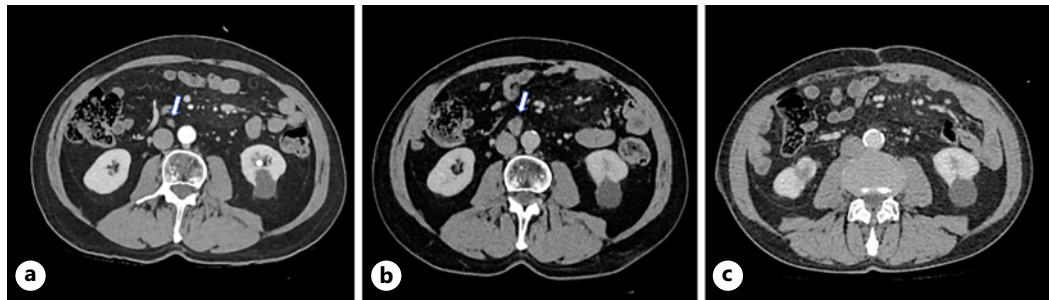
Axial computed tomography (CT) showing metastatic disease progression (arrows indicate enlarging para-aortic lymph nodes). a Initial staging CT. b Pre-operative CT scan. c Post-operative CT scan.
